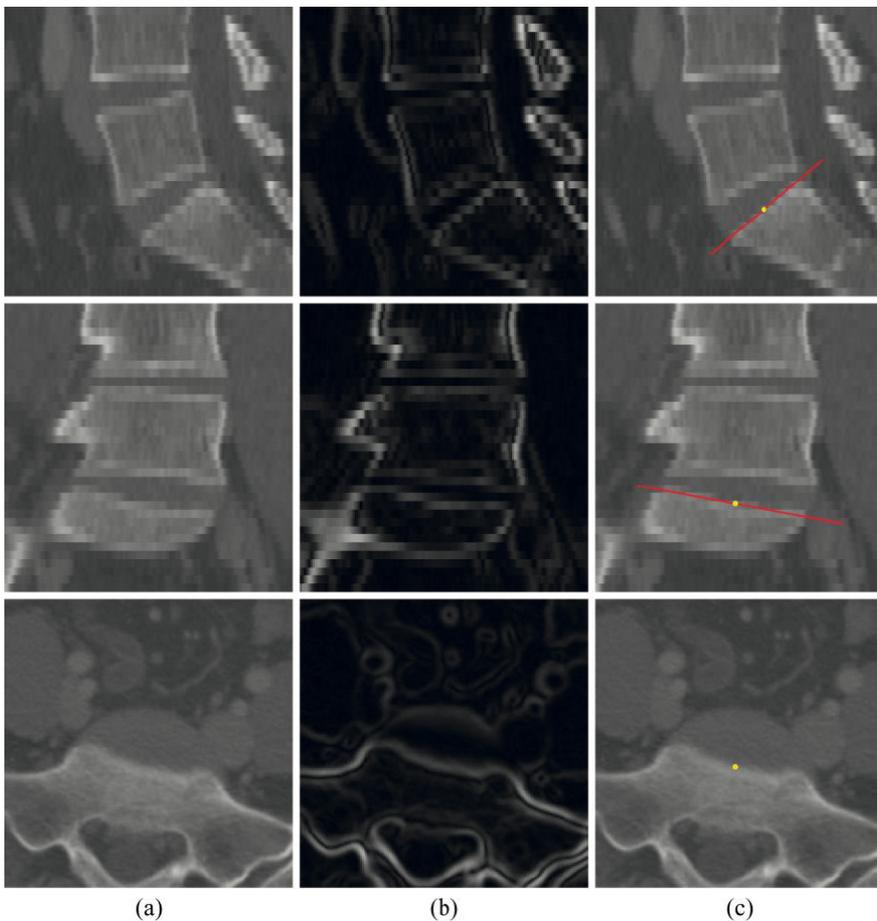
The determination of the exact center and inclination of the sacral endplate in 3-D, shown in its mid-sagittal (*top*), mid-coronal (*middle*) and mid-axial (*bottom*) CT cross-section as (a) original images, (b) magnitudes of image intensity gradient vectors, and (c) original images with the obtained center and inclination of the sacral endplate.
